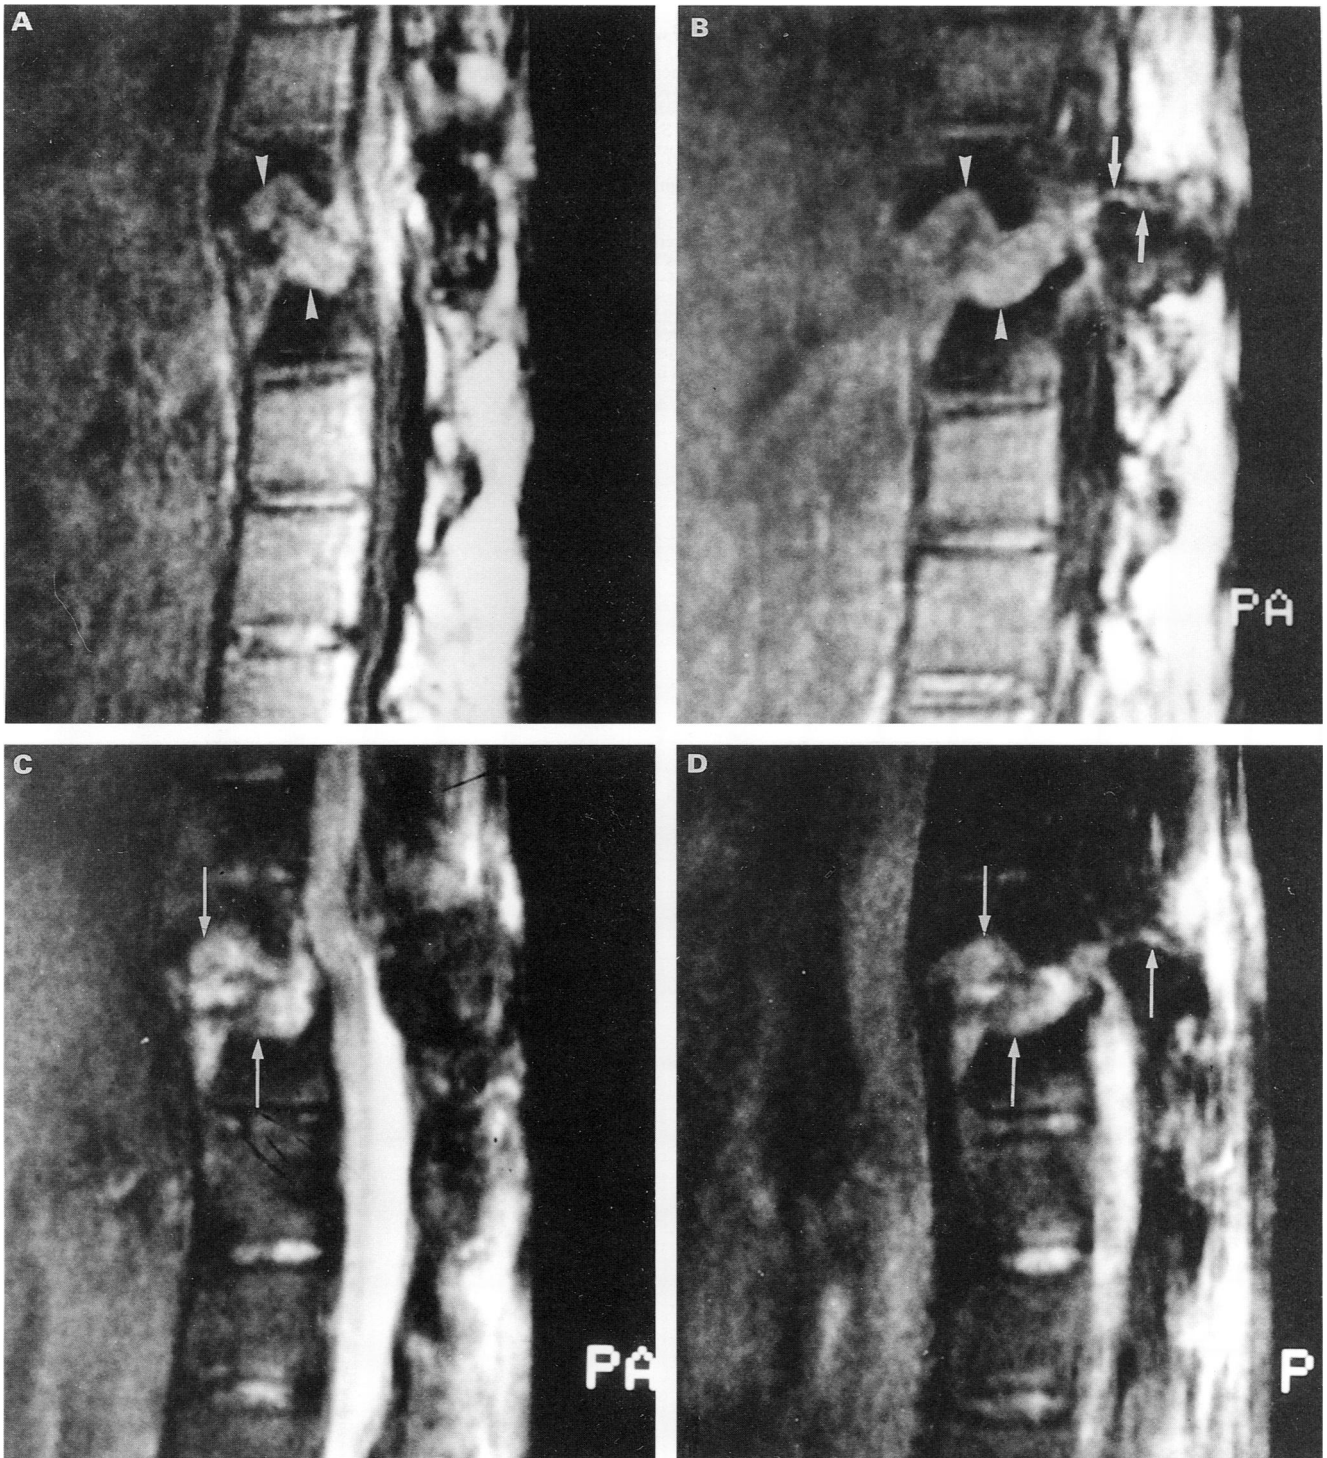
MRI of 30 year old man with ankylosing spondylitis. T1 weighted (A) mid sagittal and (B) parasagittal images demonstrate the pseudoarthrotic site as a band of intermediate intensity running obliquely through the T11/T12 disc space (arrowheads) and fused T11 posterior elements (arrows). There is loss of normal signal in the adjacent vertebral bodies. Corresponding T2 weighted images, figures (C) and (D), show linear high signal intensity (long arrows) consistent with vascularised fibrous tissue and organising exudate found in pseudoarthrosis.
